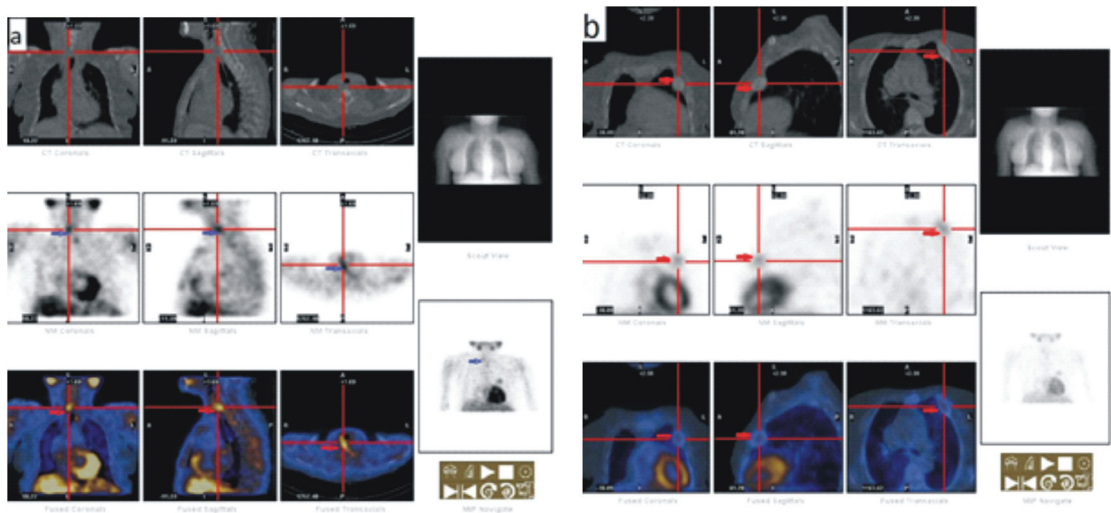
(a) Single photon emission tomography + X-ray computed tomography (SPECT-CT) images showed a photon-avid focus in the neck in the region of upper pole of right lobe of thyroid (blue arrows) (b) SPECT-CT images of Tc-99m MIBI scan, showing a distinct photon avid focus in the chest on left side as bone density lesion (red arrows) measuring 1.1×1.2 mm involving left 3rd rib near the costochondral junction.
